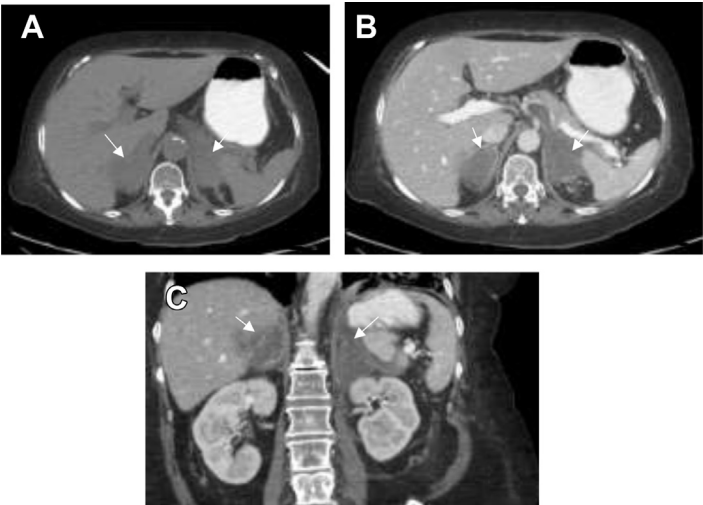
A 70-year-old patient with a history of Burkitt lymphoma presented with adrenal insufficiency due to lymphomatous involvement of the bilateral adrenal glands. Axial unenhanced CT (A), and axial (B) and coronal (C) enhanced CT demonstrate bilateral enhancing adrenal masses (arrows).
